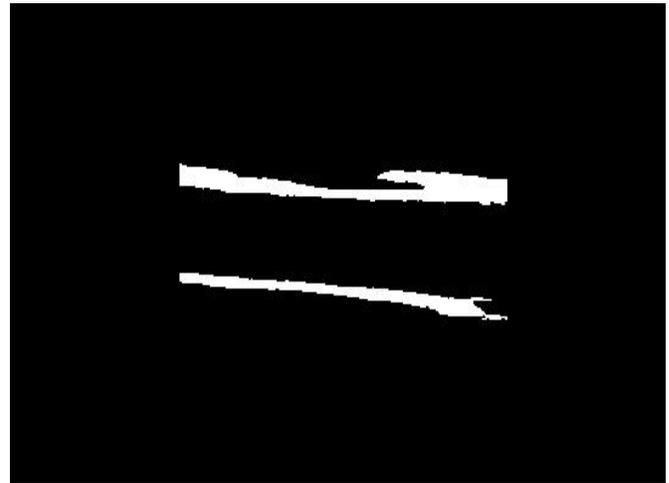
Ultrasound image of carotid artery wall after successfully being segmented
